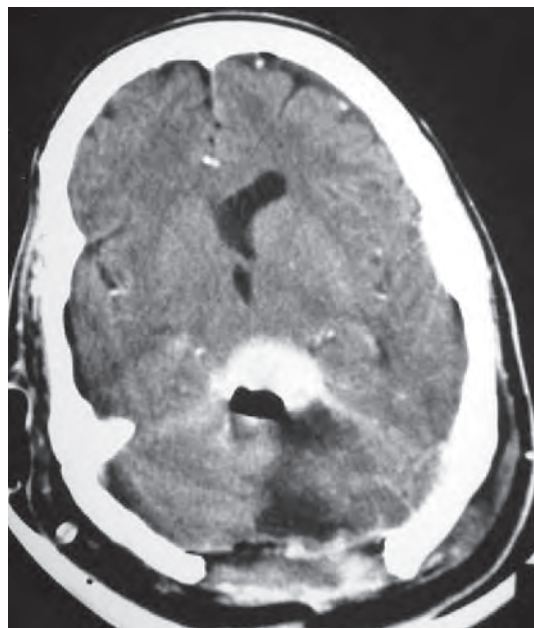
Post-operative contrast enhanced axial CT scan of the patient approached via midline suboccipital craniectomy and infratentorial supracerebellar approach. A small part of the lesion in close proximity to the Galenic venous system and the straight sinus was left *in situ*
